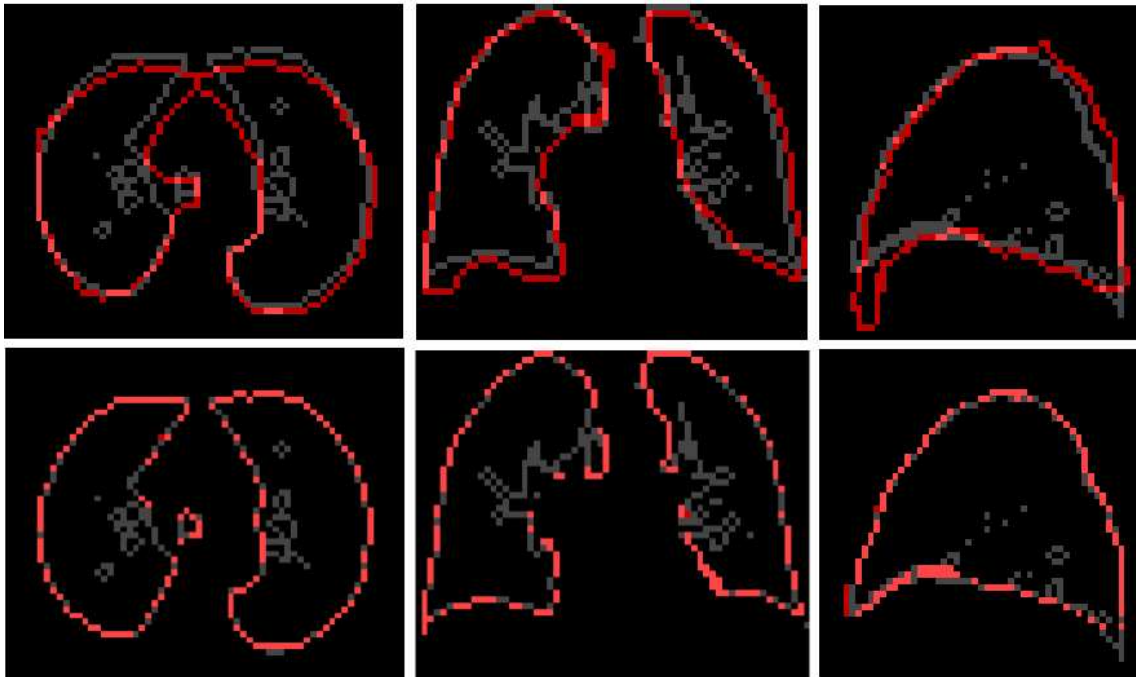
PET lung contours (red) registered with the rigid transformation provided by the classical ICP registration method (top) and non-rigid projection (bottom), superimposed on the homologous CT lung contours (grey).
